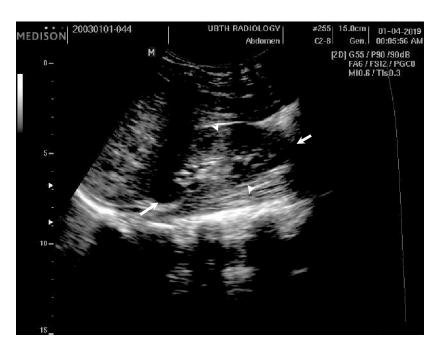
A trans-abdominal B-mode sonogram showing a longitudinal section of the right kidney and the points of measurement of renal length (long arrows) and thickness (arrow heads)
